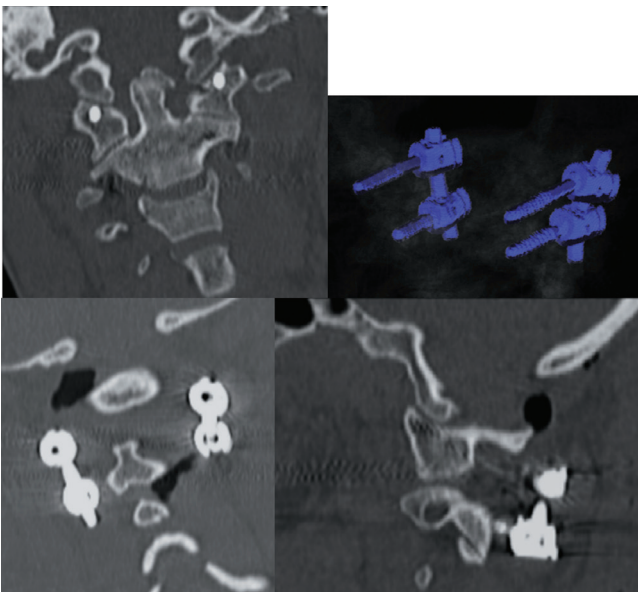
Postoperative computed tomography scan.
